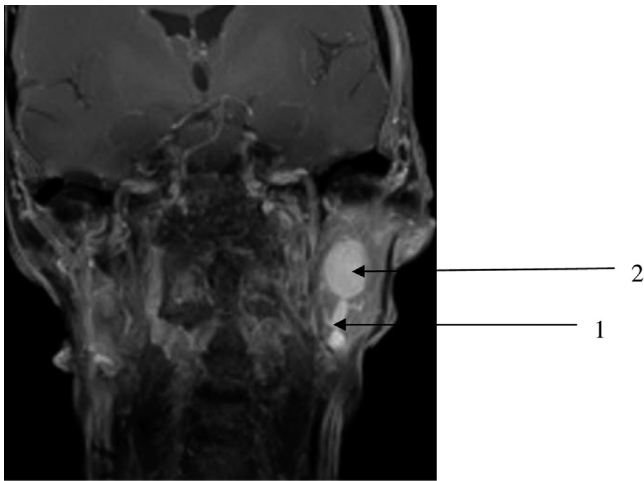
MRI T1 coronal section: visualisation of the external carotid artery (1) and the pseudoaneurysm mimicking an intra-parotid mass (2).
